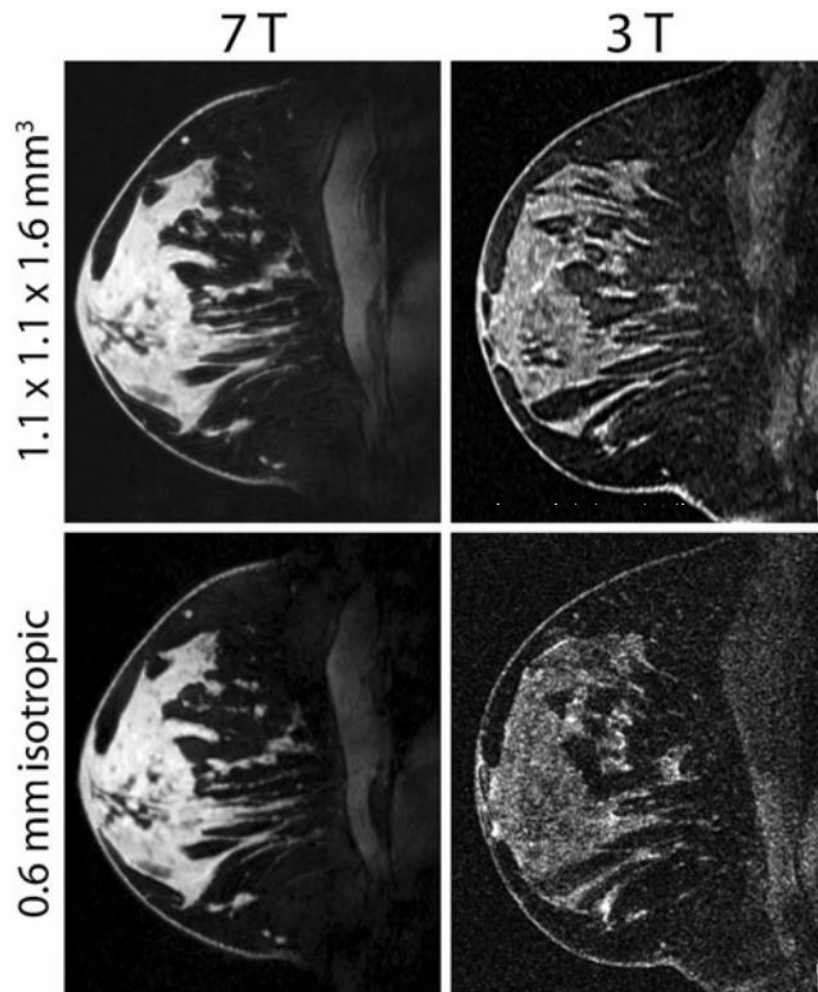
Comparisons between 3 T (right column) and 7 T (left column) breast images from the same subject with standard resolution (top row) and high resolution (bottom row) obtained with T1-weighted fat suppression (FS) sequence [4]. (Reproduced with permission.)
